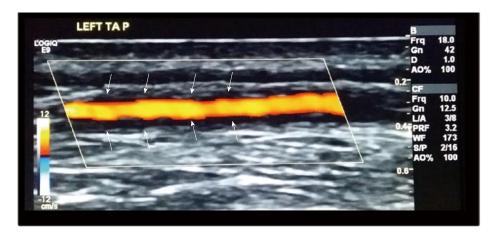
Ultrasound of the left temporal artery showing a dark halo (arrows) around the vessel wall of the parietal branch compatible with vascular inflammation.
